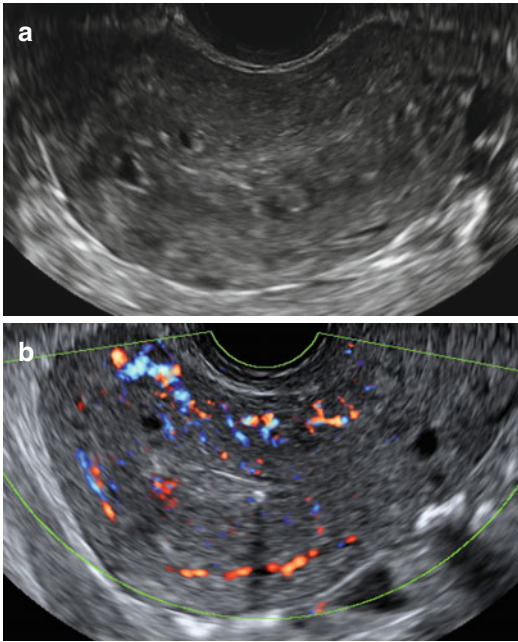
Ultrasound images of a uterus with diffuse cystic adenomyosis of the uterus. (a) Gray scale image showing several small cystic anechoic areas and hyperechoic islands in the myometrium, note the ill-defined endometrial stripe. (b) Power Doppler image showing diffusely spread vessels in the affected myometrium
